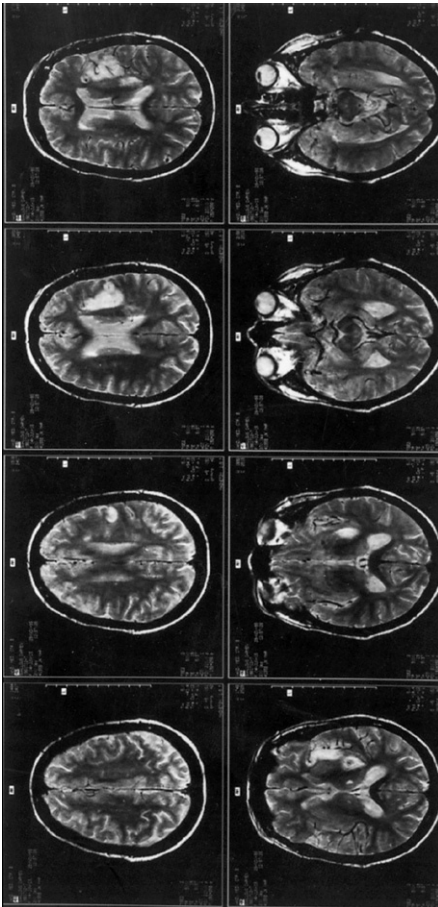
MRI imaging study in a patient with Broca's aphasia caused by infarction of Broca's area, subcortical white matter and the insula
